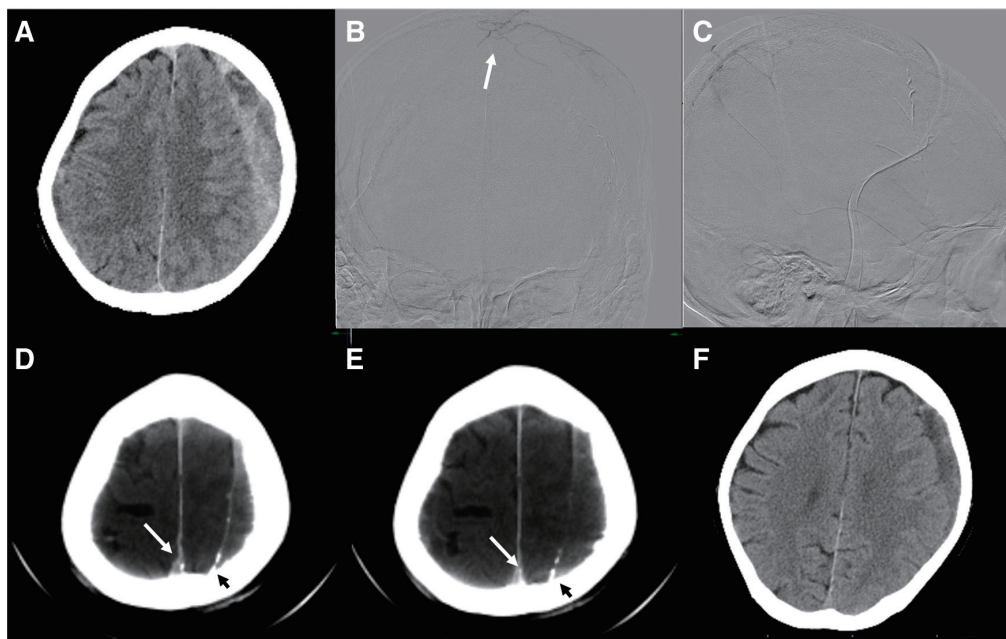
MMAE for CSDH. (A) A male in his 50s, who complained of mild gait disturbance, was found to have a left CSDH. Due to his comorbidity, burr-hole drainage is not performed, and MMAE is conducted upfront instead. The blank roadmap during a 12.5% NBCA injection (B. AP view; C. lateral view) shows that the embolic material penetrates well to the midline (white arrow in B, labeled as “bright falx sign”). (D and E) Cone beam CT immediately after the embolization shows NBCA penetration to the midline (white arrows) and to the inner layer of the hematoma (black arrows). (F) Two months after the procedure, CT reveals a significant decrease in the hematoma volume. The patient’s gait disturbance resolves immediately after the procedure. CSDH, chronic subdural hematoma; MMAE, meningeal artery embolization; NBCA, N-butyl cyanoacrylate
